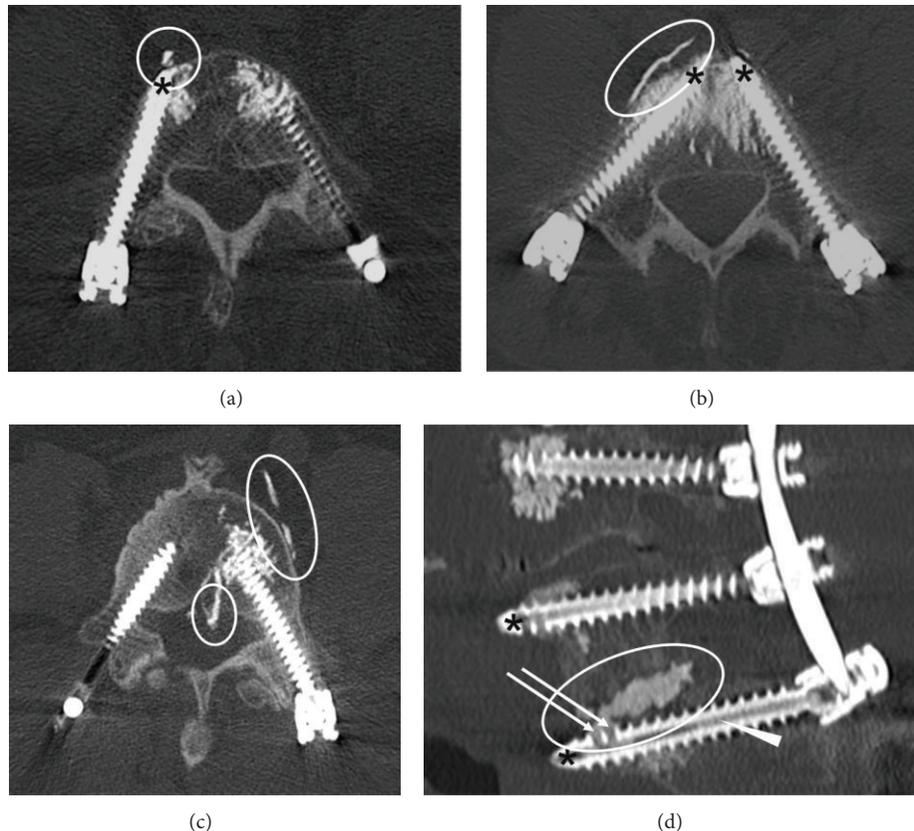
Cement extravasations. Postoperative computed tomography scans showing prevertebral ((a), (b)), paravertebral (c), epidural (c), and intradiscal (d) cement extravasations (encircled). Arrows (d) indicate fenestrations in the distal third of the thread; the arrowhead (d) indicates the hollow central shaft of the cannulated screw now filled with PMMA cement. Long screws with the tip of cannulated screws close to the anterior cortex of the vertebra (asterisks) might provoke prevertebral and paravertebral cement extravasations. Notice that the right screw (c) has not been cement-augmented due to local sclerosis of the vertebral body and therefore sufficient primary fixation strength.
